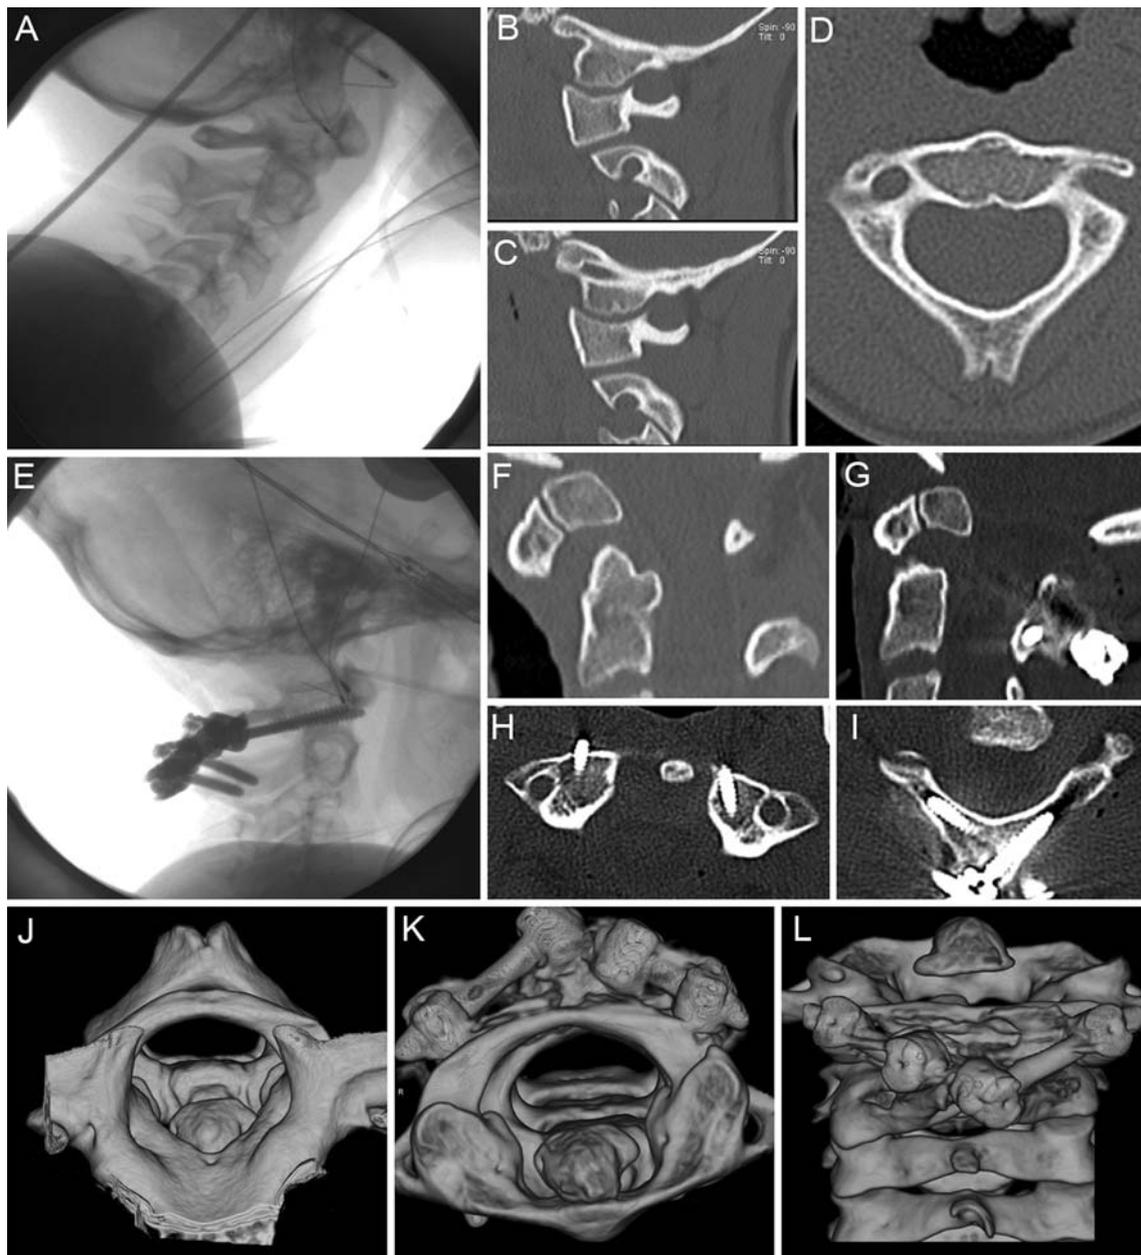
Representative radiographic images of Patient 6. Pre-operative radiograph (a) demonstrating an os odontoideum that is evident on a pre-operative sagittal CT scan (f). Sagittal images on the right (b) and left (c) an axial scan at C2 (d) demonstrated that the patient's anatomy was not ideal for transarticular screws and or C2 pedicle
